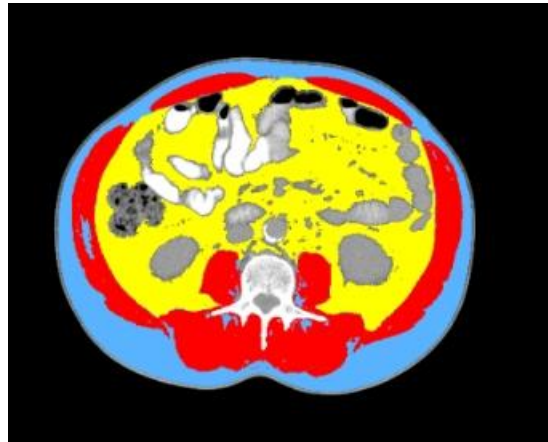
Axial CT images of the third lumbar vertebra region. CT was analyzed for muscle and fat tissue cross sectional areas and analyzed using appropriate software. SMA (shown in red) was quantified within a HU range of  $-29$  to  $150$ , VFA (shown in yellow) ranged from  $-150$  to  $-50$  HU, and SFA (shown in blue) ranged from  $-190$  to  $-30$  HU. CT = computed tomography; SMA = skeletal muscle area; HU = Hounsfield unit; VFA = visceral fat area; SFA = subcutaneous fat area.
